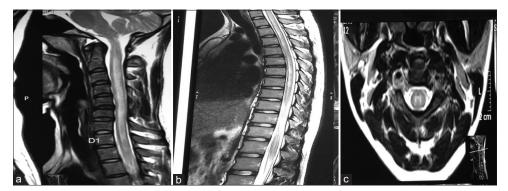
(a) MRI spine T2W sagittal image showing longitudinally extensive hyperintense signal in cervicodorsal cord. (b) MRI spine T2W sagittal image showing long segment hyperintense signals in cervical and dorsal cord. (c) MRI spine T2W axial image showing H shaped hyperintense signal involving grey matter of dorsal cord in MOG antibody positive patient
